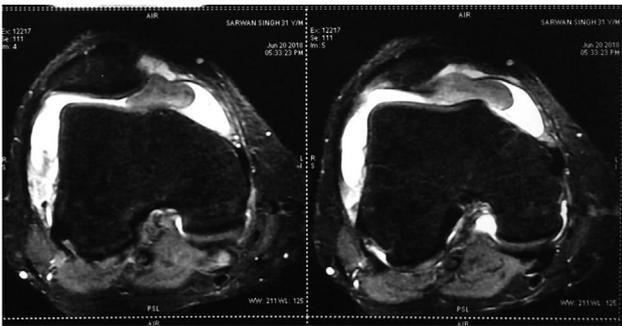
MRI of the knee joint.
